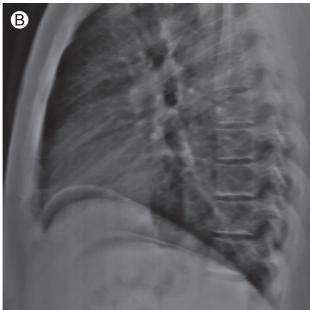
Upright posteroanterior (A) and lateral (B) chest radiographs showing pneumoperitoneum beneath the right and left hemidiaphragms.
